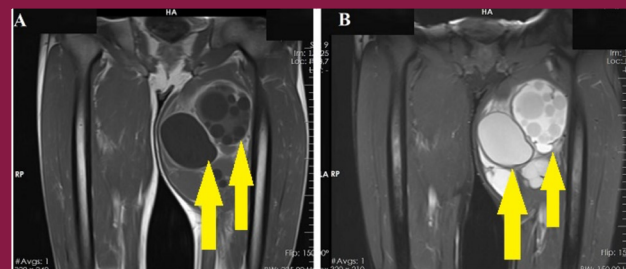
A. Coronal T1-weighted MRI study of the thigh demonstrate a large cystic lesion containing the smaller round cysts (arrow), B. Coronal T2-weighted demonstrate a large cystic lesion containing smaller round cysts (arrow)
